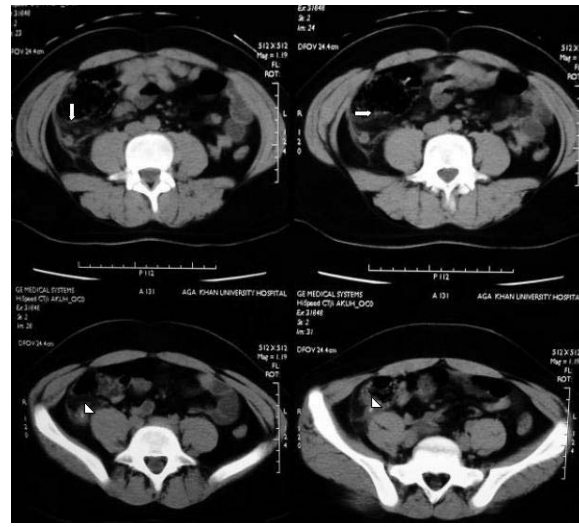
Computed tomographic images showing enlarged appendix in all four axial sections. Evidence of periappendiceal stranding (arrows) in the top two images, and luminal appendicolith in the bottom two sections (arrowheads). sensitivity of 91% and specificity of 100%.
